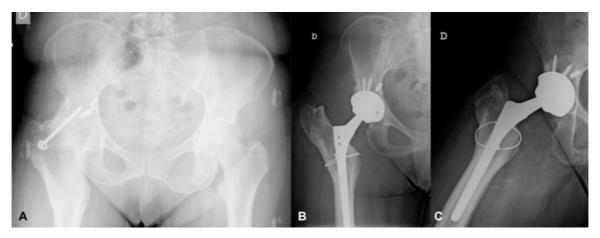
(A) radiography showing right hip arthrodesis with transarticular screws; (B), radiography showing right hip desarthrodesis at 3 years of postoperative follow-up.
